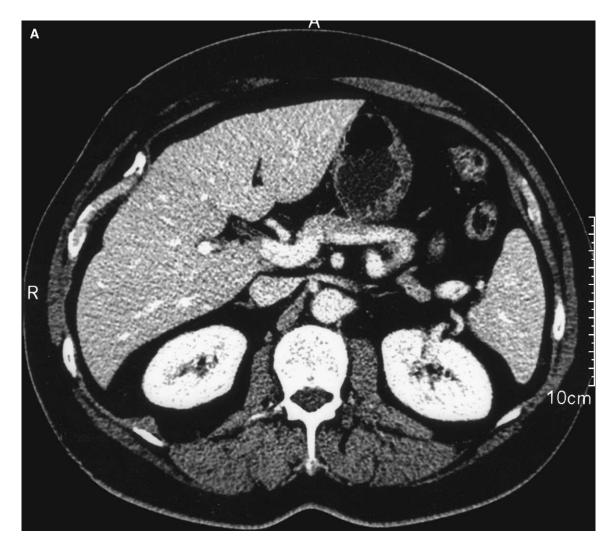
Computed tomography scans at three stages in the patient course. (A) CT scan obtained at initial presentation, with no neuroendocrine tumor visualized, and normal body and tail of the pancreas. (B) Patient following pylorus-preserving pancreaticoduodenectomy, with normal remnant body and tail of the pancreas. Fluid and air around the liver related to leak at biliary-enteric anastomosis, managed with percutaneous biliary catheter drainage. (C) New desmoid tumor visualized (*arrow* points to cystic component of desmoid mass).
